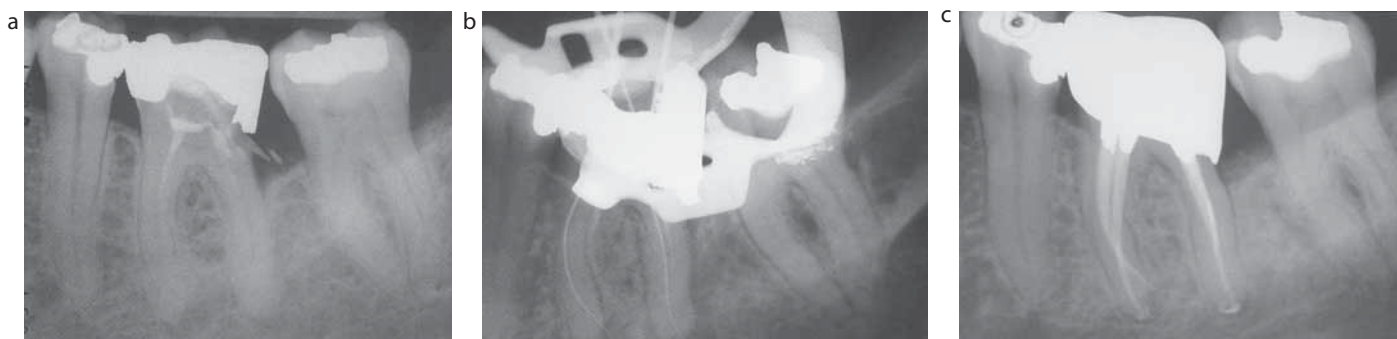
Series of radiographs showing a badly broken down lower first molar (a) which was restored with amalgam supported by a copper band prior to attempting removal of the hard paste. (b) Intermediate length determination radiograph showing hard paste still remaining deep within two of the canals. This was removed using an LN bur and ultrasonics. (c) Amalgam core and coronal restoration in place.
